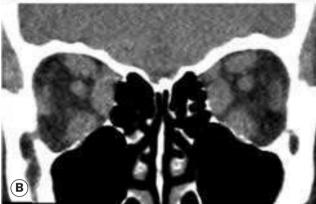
CT scan showing muscle enlargement in thyroid eye disease. (A) Axial view showing fusiform enlargement of the medial rectus muscle; (B) coronal view showing symmetrical involvement of the medial, superior and inferior rectus muscles as well as the superior oblique muscles
